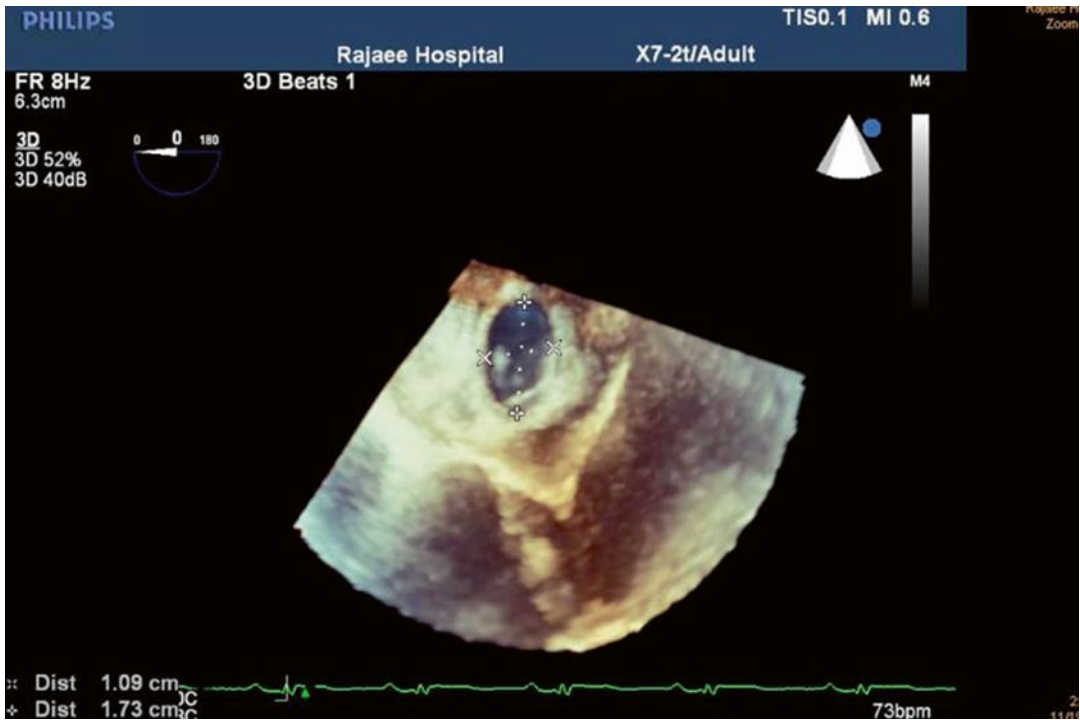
Three-dimensional transesophageal echocardiography, affording precise anatomic detail of the atrial septal defect's morphology, size, and surrounding rims
